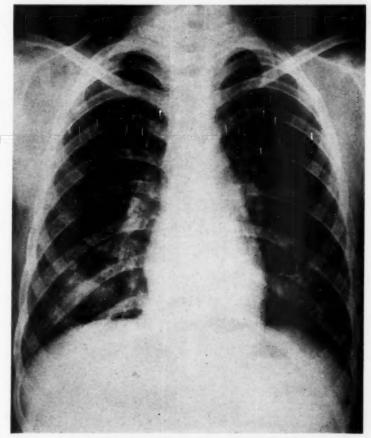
(Case 2.) Roentgenogram showing sparsity of calcium deposits in 1941.
